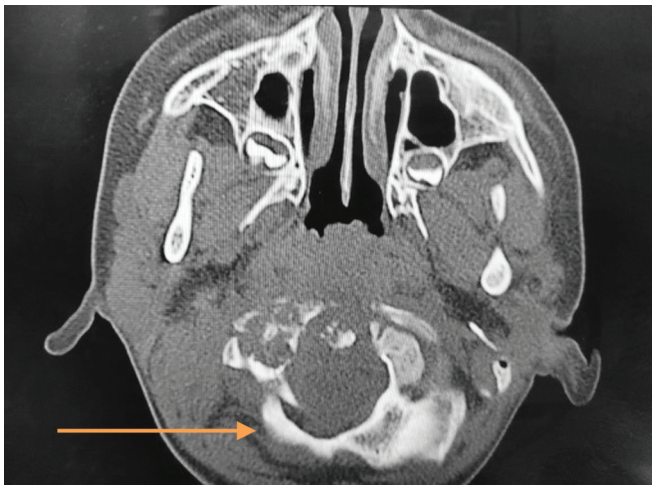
CT Brain with bone window showing erosion of atlas and occipital condyle
